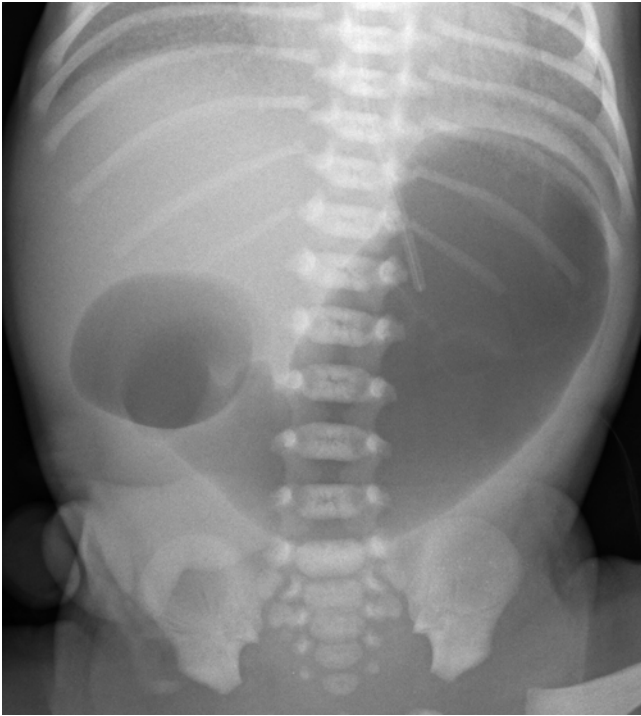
Duodenal atresia in a 1-day-old premature presented with vomiting. Abdominal radiograph demonstrates a markedly distended stomach and duodenal bulb giving the classic double bubble sign. Note lack of gas in the rest of the intestinal tracts
